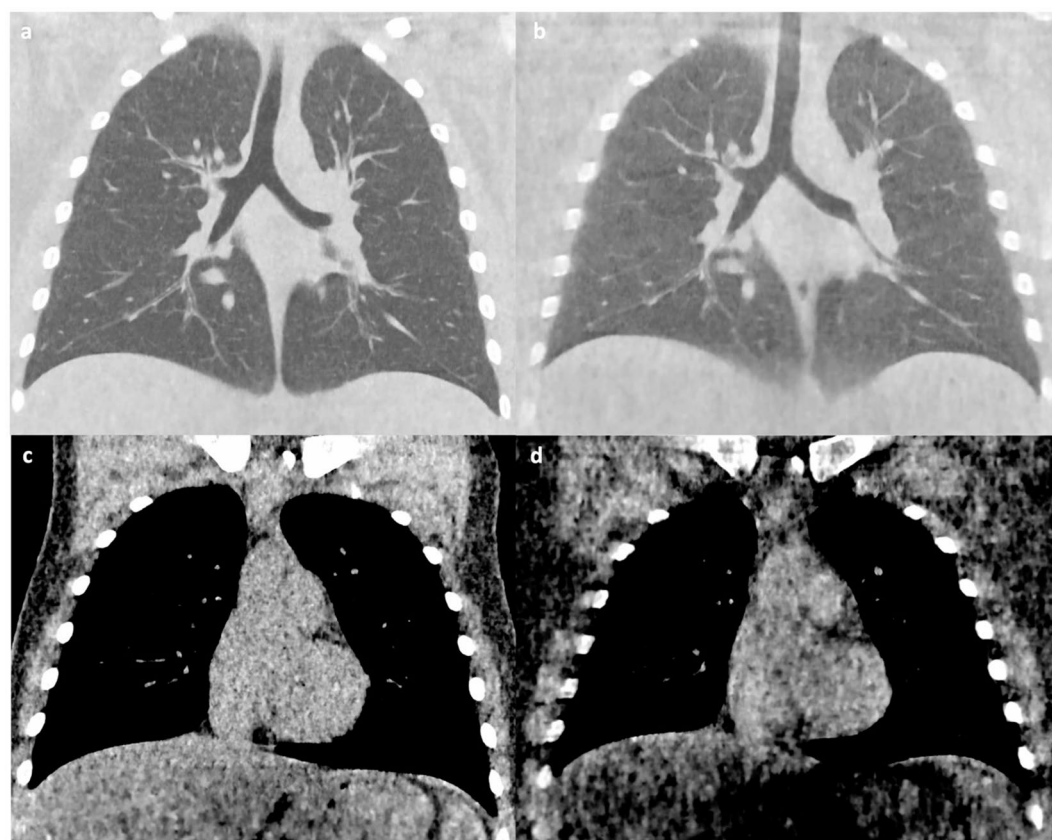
Comparison of ULDCT chest and modified low dose CT chest protocols. Comparison of coronal modified low dose chest CT images in lung windows (a) and soft tissue windows (c) with coronal ultra-low dose chest CT in lung windows (b) and soft tissue windows (d) in the same paediatric patient acquired 31 months apart. These images demonstrate the acceptable assessment of lung structure and increased noise in the mediastinum and chest wall in ULDCT chest imaging.
